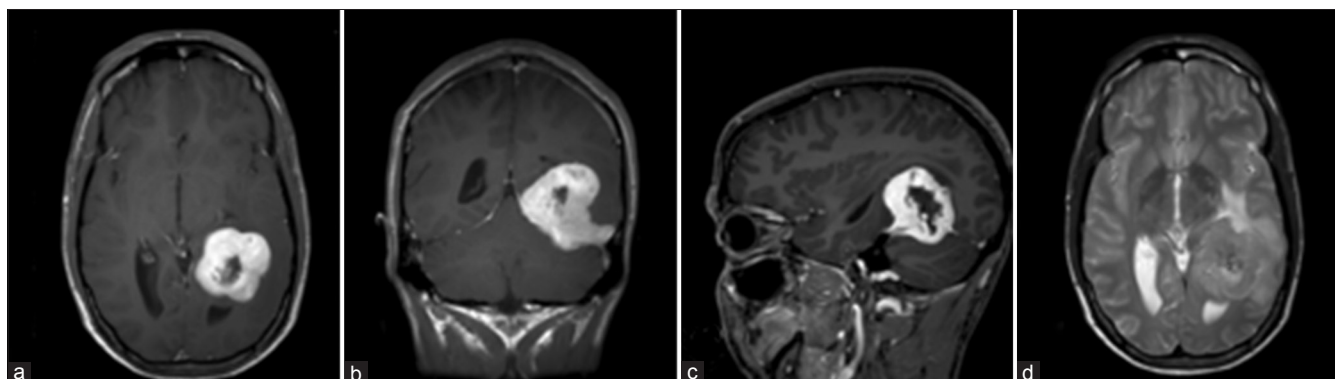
Preoperative axial (a), coronal (b) and sagittal (c) T1-weighted MRI studies showing a gadolinium enhancing extra-axial mass of the left tentorial incisure. Temporal lobe edema is seen on the axial T2-weighted MRI studies (d)
